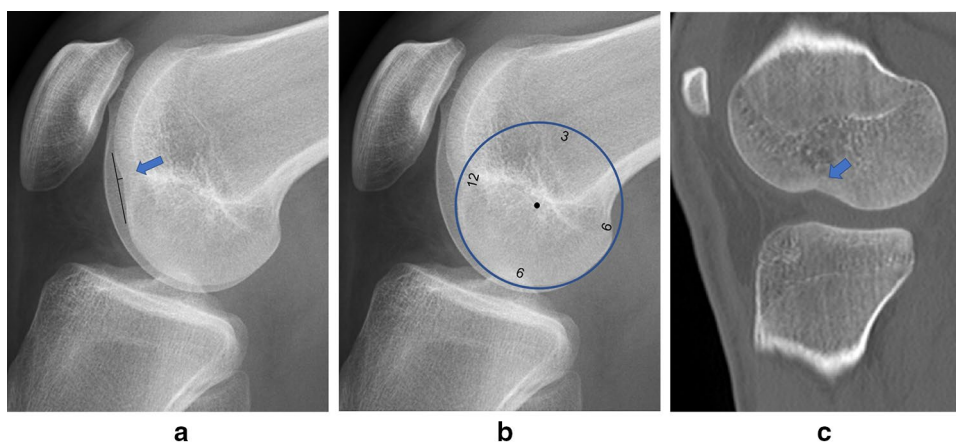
a An example of a right knee radiograph demonstrating a DLFNS > 1.8 mm. The current patient suffered a concomitant ACL/ALL rupture. The depth of the DLFNS was defined as the distance between a tangent line at the articular surface of the lateral femoral condyle and the deepest point of the DLFNS [13]. b The DLFNS
